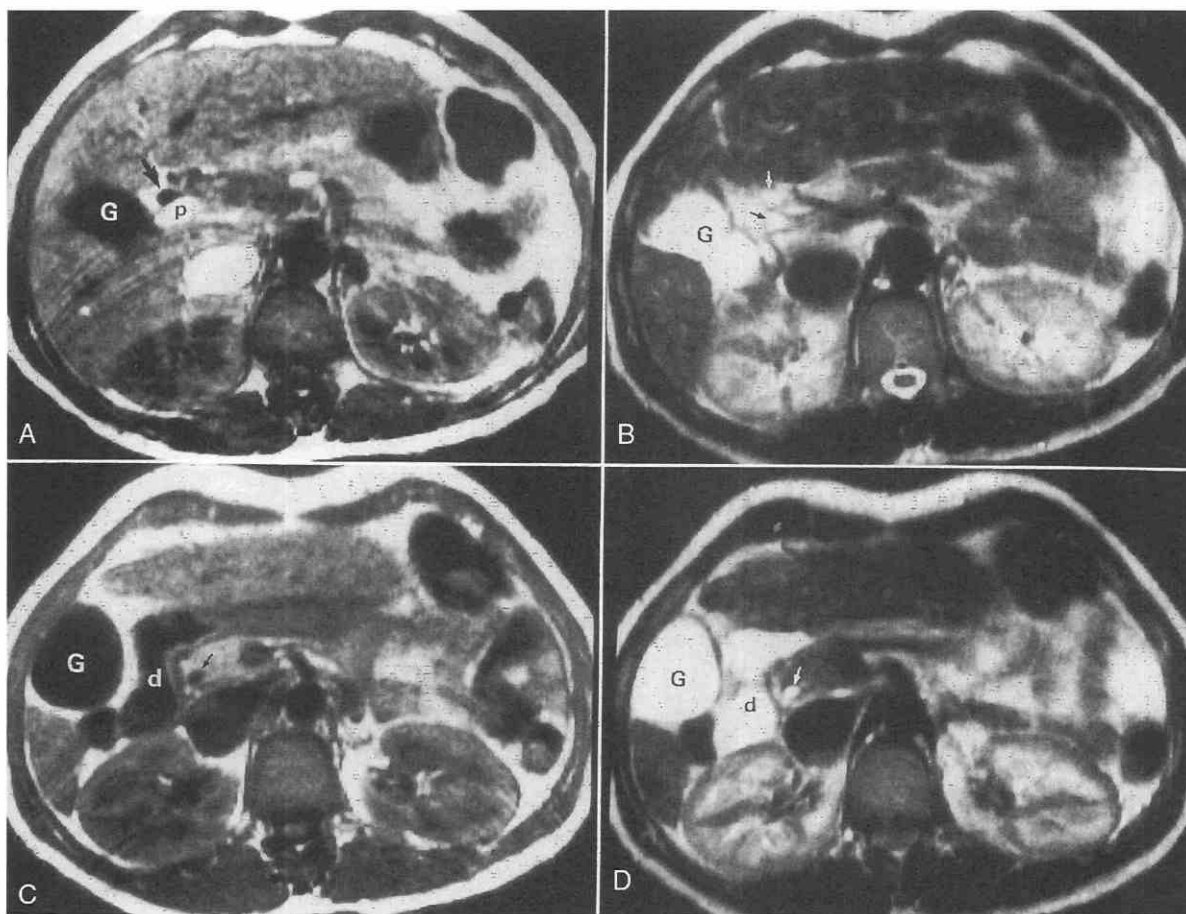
Normal extrahepatic bile duct. A, Common hepatic duct (*arrow*) is hypointense on the T1-weighted image. Gallbladder (G); portal vein (p). TR = 578; TE = 15. B, T2-weighted image at level comparable to A. Common hepatic duct (*white arrow*) is now hyperintense. Gallbladder (G); portal vein (*black arrow*). TR = 1995; TE = 90. C, T1-weighted image of distal common bile duct (*arrow*) in pancreatic head also shows gallbladder (G) and duodenum (d). TR = 578; TE = 15. D, T2-weighted image at comparable level to C. Note distal common bile duct (*arrow*) now turns hyperintense. G = gallbladder; d = duodenum; TR = 1995; TE = 90.
